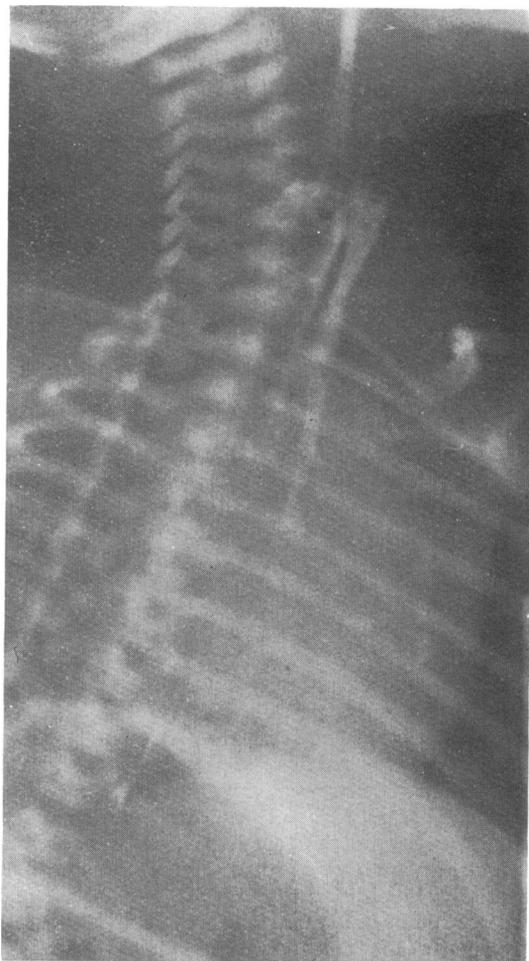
Oblique x-ray showing barium flowing from oesophagus anteriorly into the trachea.
